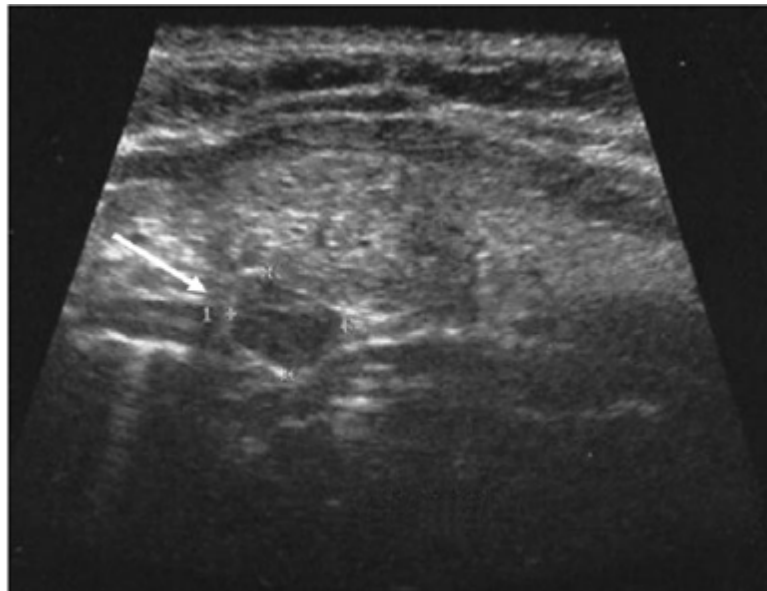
Ultrasonography of the neck in patient II-8 shows an extrathyroidal 10-mm diameter nodule below the left thyroid lobe (white arrow) consistent with a parathyroid mass.
